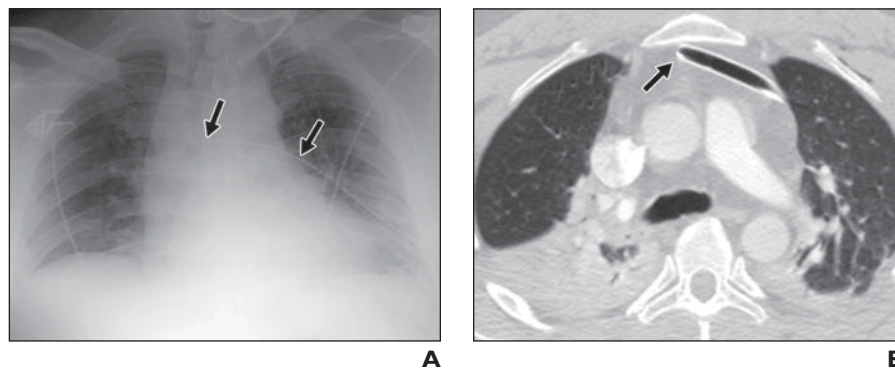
37-year-old man with mediastinal placement of chest tube. A, Anteroposterior chest radiograph shows left chest tube (*arrows*) in inappropriate position, directed medially and projecting across mediastinum. There is persistent left pleural effusion. B, CT image at level of pulmonary artery trunk confirms that tip of chest tube (*arrow*) is in anterior mediastinum.
